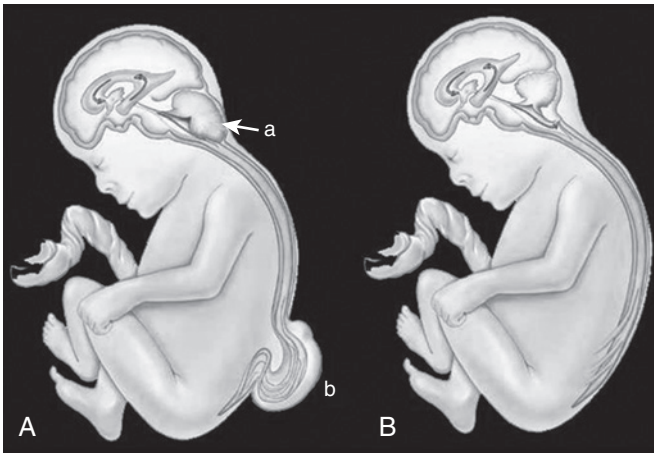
Pathogenetic formulation for the Chiari type II malformation and the effect of treatment. See text for details. In (A) Chiari malformation (a) and the open myelomeningocele (b) are shown. The negative pressure generated from drainage of cerebrospinal fluid from the open myelomeningocele (b) results in the inferior displacement of the cerebellum (a) and thereby the Chiari type II malformation. (B) After fetal closure, positive back pressure reduces the cerebellar hernia and expands the posterior fossa. (From Sutton LN, Adzick NS, Bilaniuk LT, Johnson MP, et al. Improvement in hindbrain herniation demonstrated by serial fetal magnetic resonance imaging following fetal surgery for myelomeningocele. *JAMA*. 1999;282:1826–1831.)
